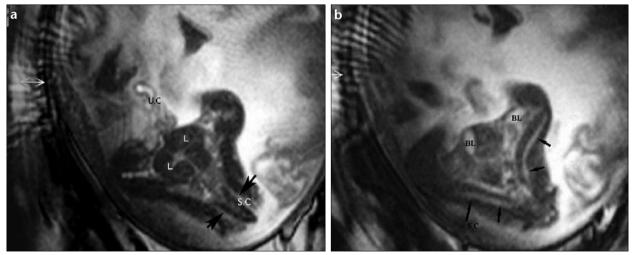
a, b. Coronal MR images demonstrate polyhydroamnios, umbilical cord (U.C), and fused livers (L) (a). Two spinal columns (S.C.) (arrows) and bladders (BL) are shown (b).
